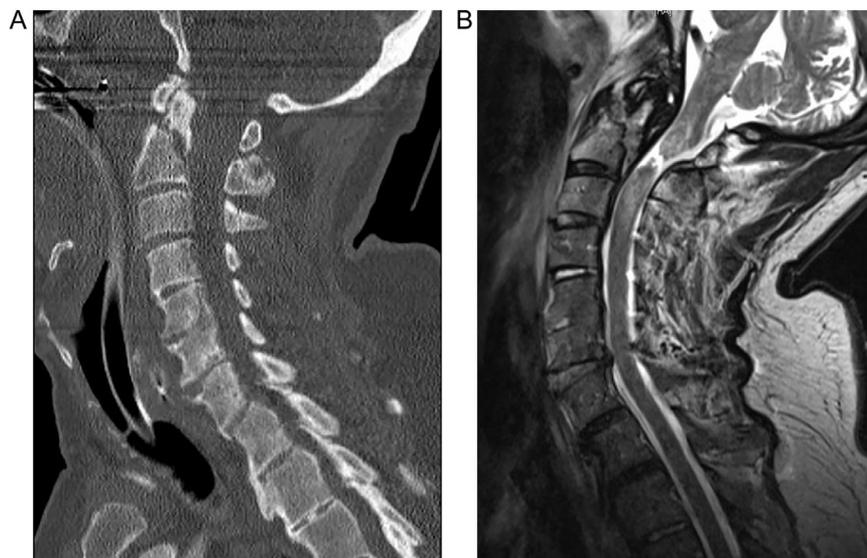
(A) The CT shows a type III odontoid fracture through the base of the dens, extending into the dorsal aspect of the C2 vertebral body and the medial part of the right C1–C2 facet. The odontoid fragment is displaced posteriorly (4 mm) relative to the body of C2, mildly narrowing the central canal. At C6/C7 level is a mild anterior disk widening. (B) MRI shows a Type II odontoid fracture with C2 complete cord transection, marked cord swelling and hemorrhage in the cord cephalad to this level and down to the C3–4 level. At C3–4 and C6–7 shows acute hyperextension injuries with anterior discs widening and hyperintensity.
